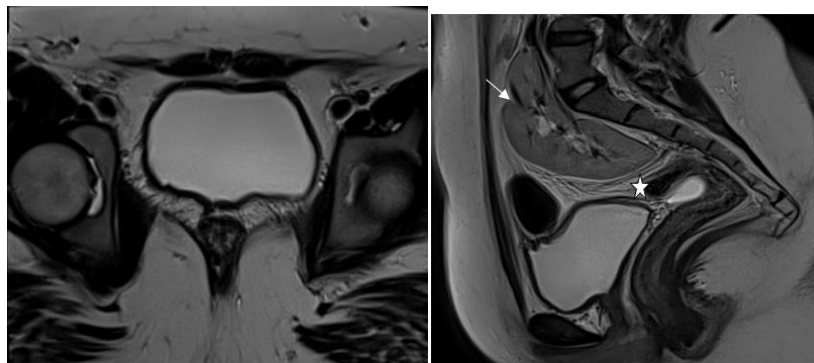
Pelvic MRI; axial and sagittal T2 sequences: uterine agenesis (star) with left kidney in pelvic position (arrow)
